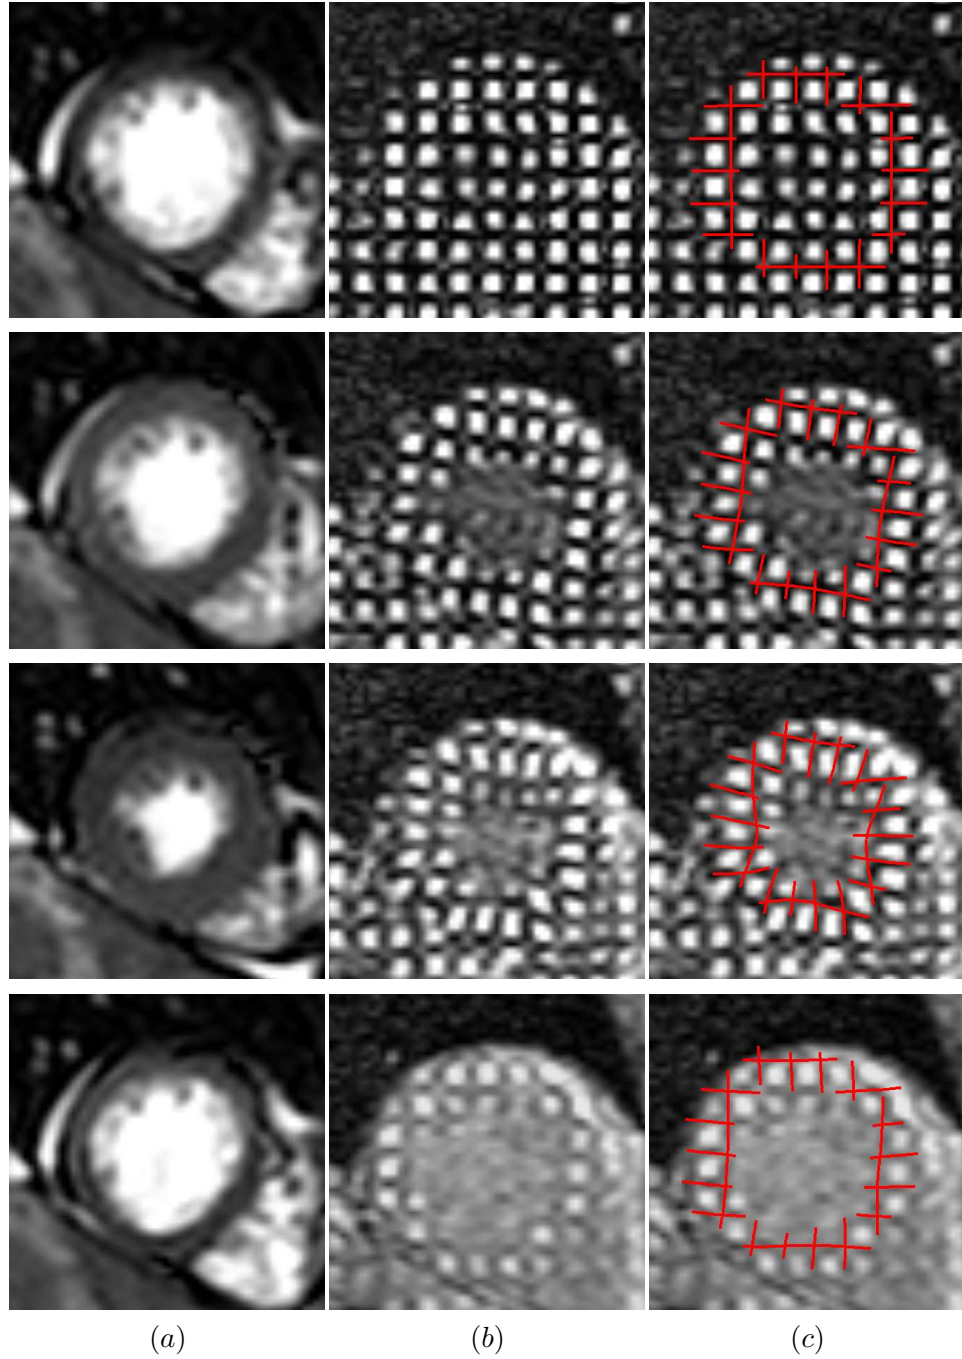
A midventricular short axis slice from the anatomical cine MRI scan is shown in (a) over the cardiac cycle (first row: ED, third row: ES). The corresponding slice in the tagged cine MRI scan is shown in (b). The slice from (b) is overlaid with virtual tag lines in (c). The virtual tag lines were generated by applying the deformation recovered from the anatomical scan to the manually positioned tag planes at ED. The images are from the second scan of the healthy volunteer.
